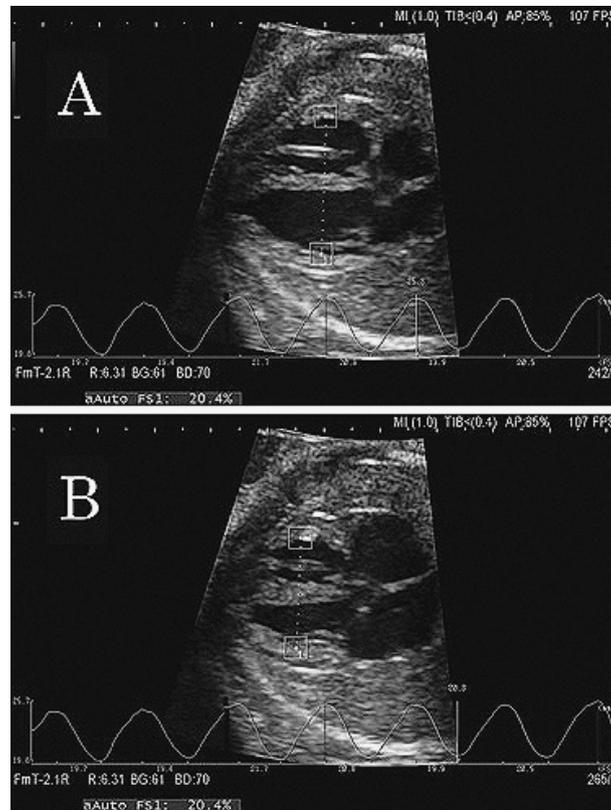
The ultrasonogram of Auto FS measurement. The region-of-interest follows the myocardium contracting in the minor axis direction and the major axis direction.
